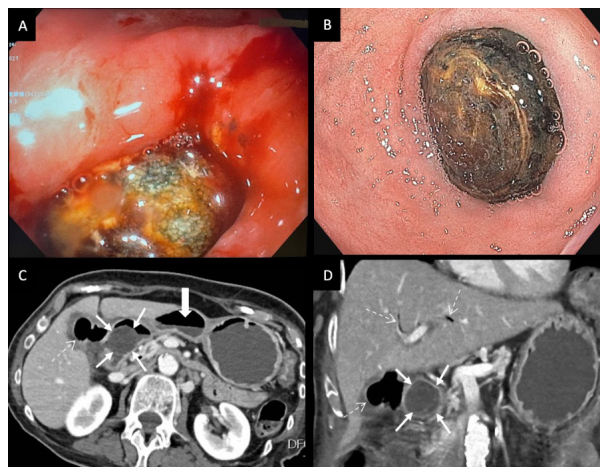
A + B. Upper endoscopy revealing a large impacted gallstone in the duodenal bulb. C + D. CT scan imaging showing a bilioenteric fistula with air in the gallbladder and pneumobilia (dotted arrow), a large gallstone of 25mm (arrows) impacting the bulb and the stomach filled with fluid and air-fluid levels (large arrow).
